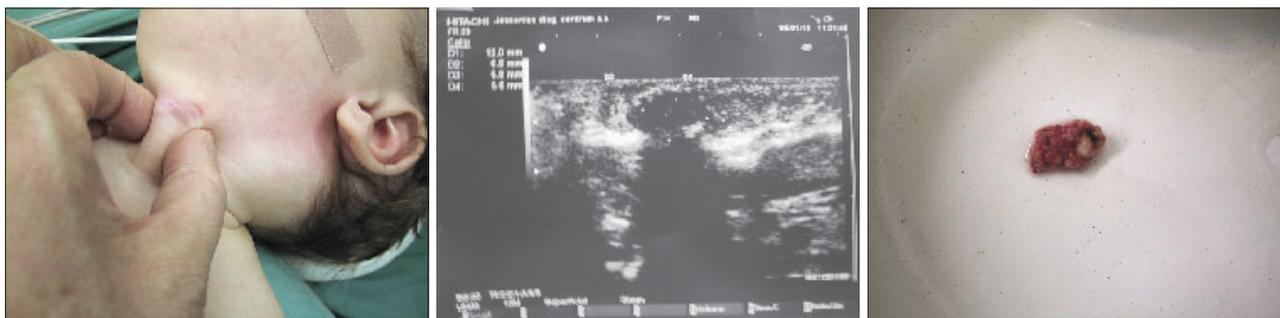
a) A firm mobile lesion on the anterior aspect of the neck. b) Ultrasonography of the neck showed two subcutaneous masses. c) The removed lesion with resection of overlying skin.
